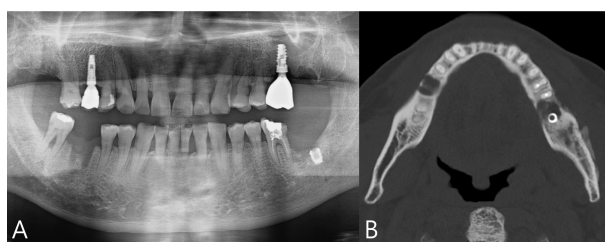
Initial panoramic radiograph (A) and computed tomography (B) depicting an osteolytic lesion around extraction socket and dental implant.
